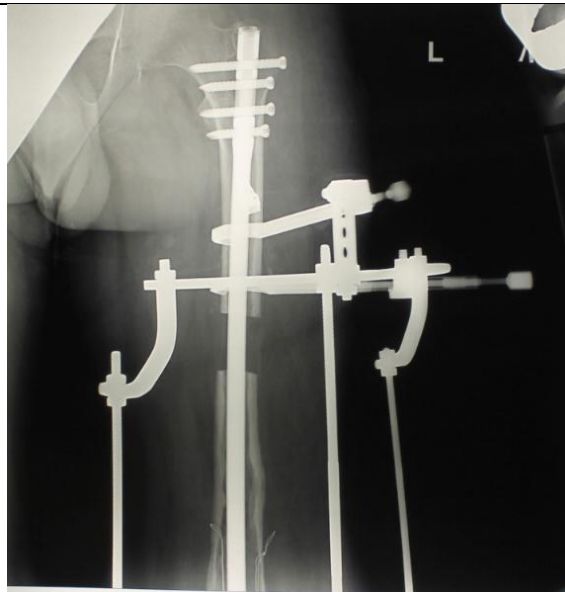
X-ray films of patient A., 20 y.o., with coxa vara congenita: a – during lengthening over retrograde nail (SUV-clamps are pointed by arrows); b – after distraction, proximal locking and ExFix frame removal
